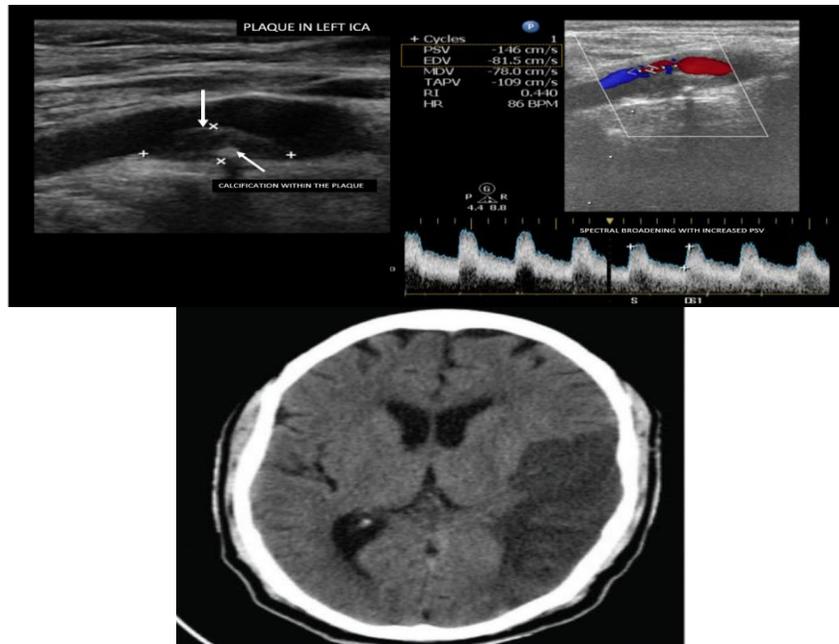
Image showing type II plaque in bulb extending to ICA with increased PSV resulting in 50-69% stenosis, corresponding CT Brain shows large acute infarct in left MCA territory.
